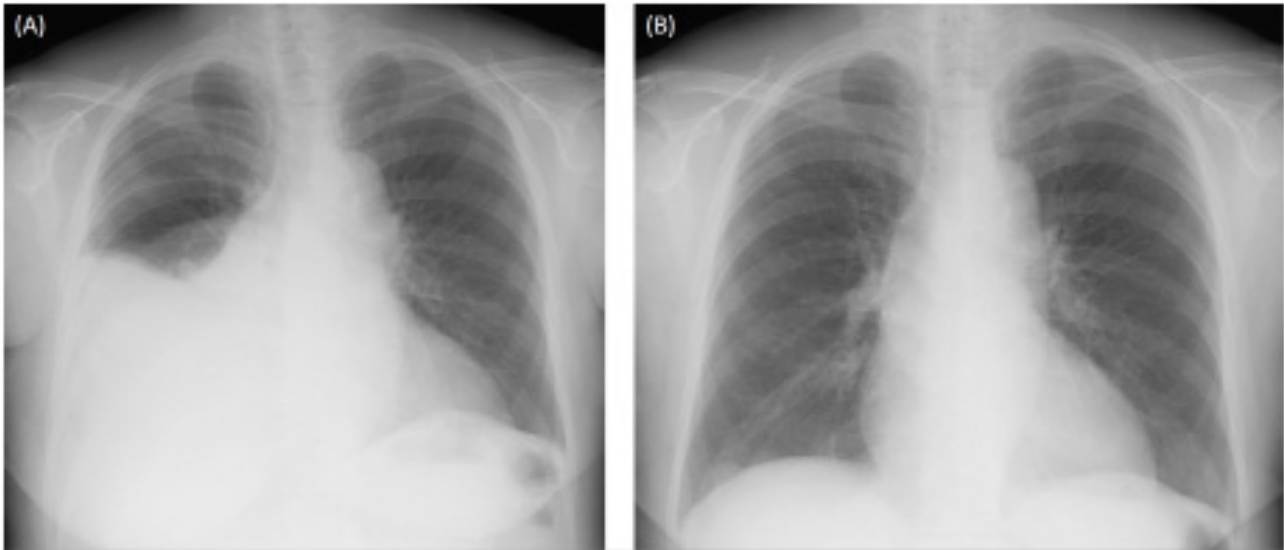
A: Chest radiography showing a right-sided pleural effusion. B: Chest radiography showing no evidence of a pleural effusion 5 months before admission.
